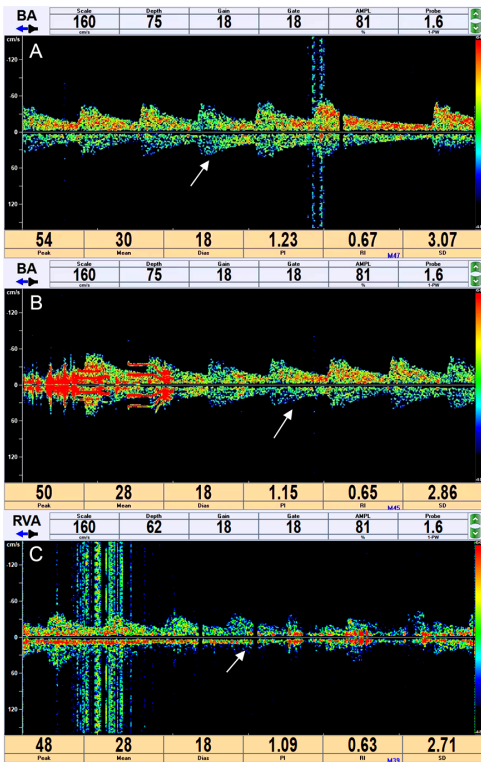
TCD image of the brain in a typical CSVD patient. A is from a TCD image of a 66-year-old patient. B is from a TCD image of a 58-year-old patient. C is from a TCD image of a 61-year-old patient. The numbers above and below the images demonstrate the patient's blood flow parameters. The arrows demonstrate the lesion areas in the images. TCD: transcranial Doppler. CSVD: cerebral small vessel disease.
